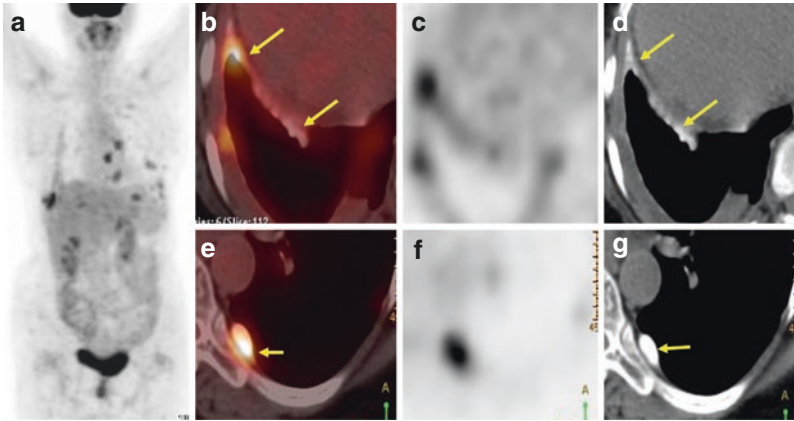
Whole-body FDG PET/CT scan of a 65-year-old lady with recurrent malignant bilateral pleural effusion. She had undergone pleurodesis 5 months prior to the FDG PET scan. MIP (a) and axial images (b–g) show FDG-avid linear and nodular areas of talc deposition which are seen as high attenuation areas in the CT image (d, g). This occurs due to the inflammatory reaction in the pleura due to instillation of talc to obliterate the pleural space
